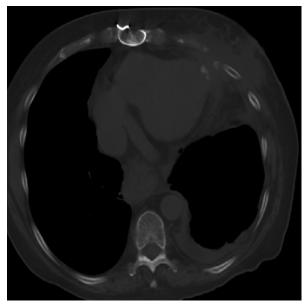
Computed tomogram without contrast medium shows no evidence of the aneurysm at 4 postoperative weeks.
